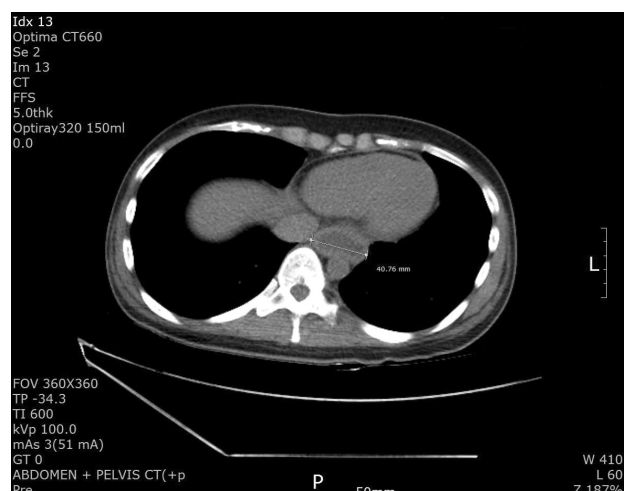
Dilatation of the distal esophagus on the preoperative computed tomography.
